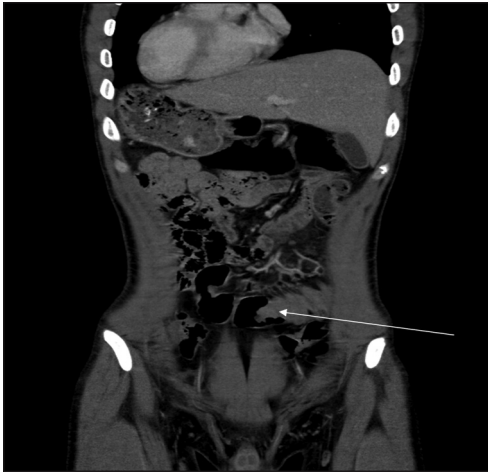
Contrast-enhanced CT scan of the abdomen demonstrated situs inversus totalis with apex of the heart, stomach and spleen resting on the right side and the liver on the left side of the abdomen and ileocolic intussusception which creates characteristic bowel-within-bowel appearance, seen in left iliac fossa (white arrow)
